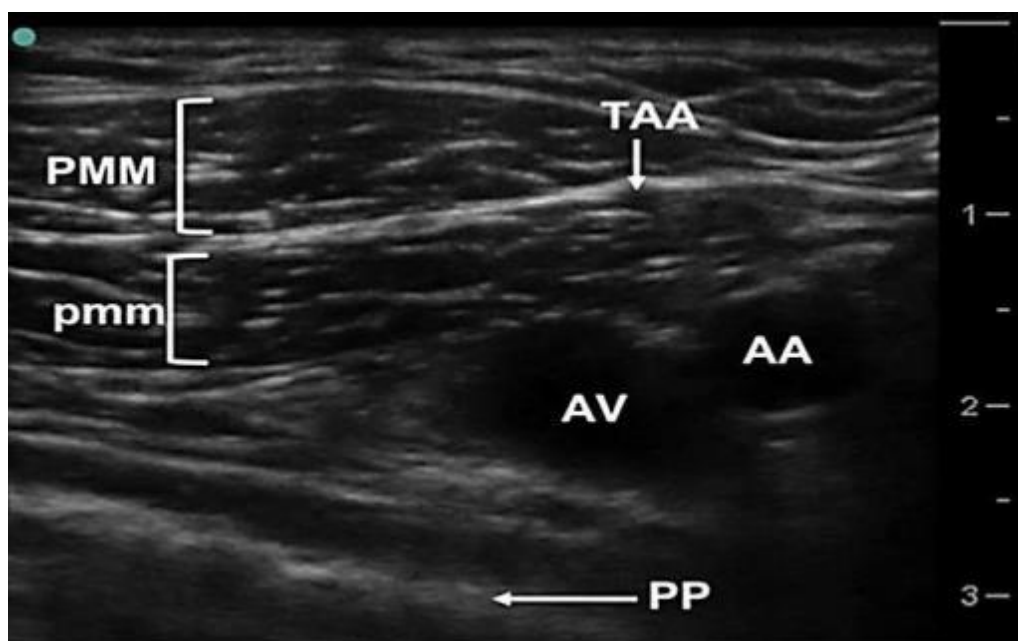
Ultrasound visualization for pectoral nerve block I. The pectoralis major muscle (PMM), pectoralis minor muscle (pmm), thoracoacromial artery (TAA), axillary artery (AA), axillary vein (AV), and parietal pleura (PP) are identified (14).
